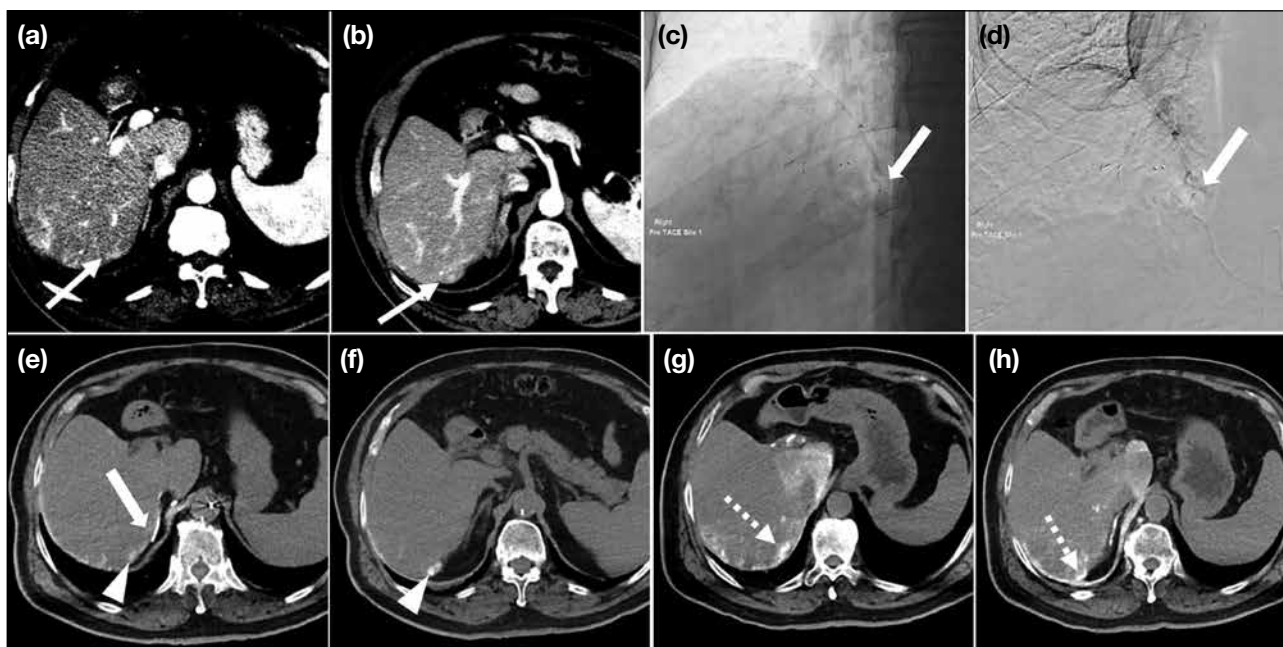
A 77-year-old patient. (a, b) Contrast computed tomography (CT) of the liver in late arterial phase shows several faint enhancing lesions in the right hepatic lobe suspicious for recurrent hepatocellular carcinoma (arrows). Contrast CT was unable to identify the extrahepatic feeding artery. Given the location of these lesions, the right inferior phrenic artery was thought to be one of the common extrahepatic supplies. (c, d) The right inferior phrenic artery was cannulated with a 1.7-Fr microcatheter (arrows) [Merit Pursue; Merit Medical Systems, Warrington (PA), United States]. (d) Digital subtraction angiography shows no sizable tumour blush. (e, f) Angiography-computed tomography (angio-CT) with intra-arterial injection of the right inferior phrenic artery confirmed it supplying the right hepatic lesions (arrowheads). A chemotherapeutic mixture was administered via microcatheter (arrow in [e]). (g, h) Postprocedural plain CT on the angio-CT system performed after several additional sessions of transarterial chemoembolisation, shows dense lipiodol uptake (dashed arrows) and a reduction in lesion size, as seen in (h).
